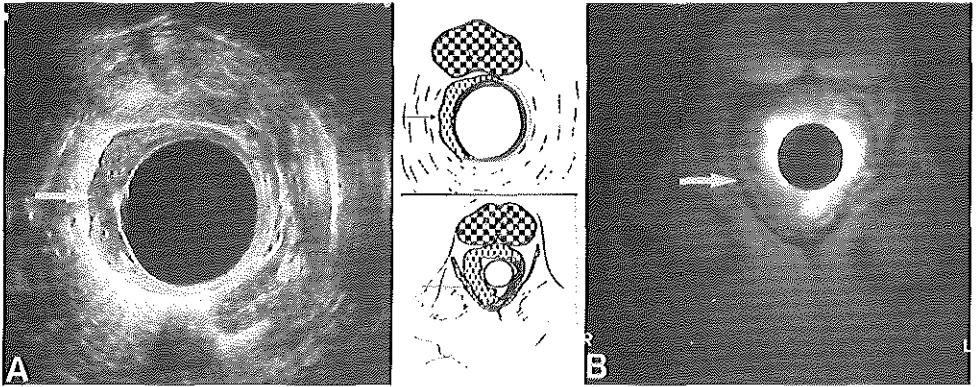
Rectal *pT2* tumor. Transrectal ultrasound (A) versus transrectal MRI (B). Axial images showing the tumor (arrow) limited to the muscularis propria. Correct staging with both imaging techniques.
